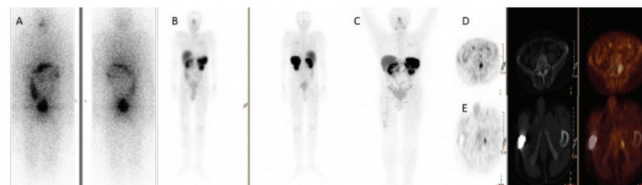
(Case 1). A) 5 mCi I-131 anterior and posterior whole body images B) 3rd cycle Lu-177-DOTATATE on day 3 after treatment anterior and posterior whole body images C) Ga-68-DOTATATE PET / BT MIP image before treatment D, E) Ga-68-DOTATATE PET / CT PET, CT and PET-CT fusion images before treatment
